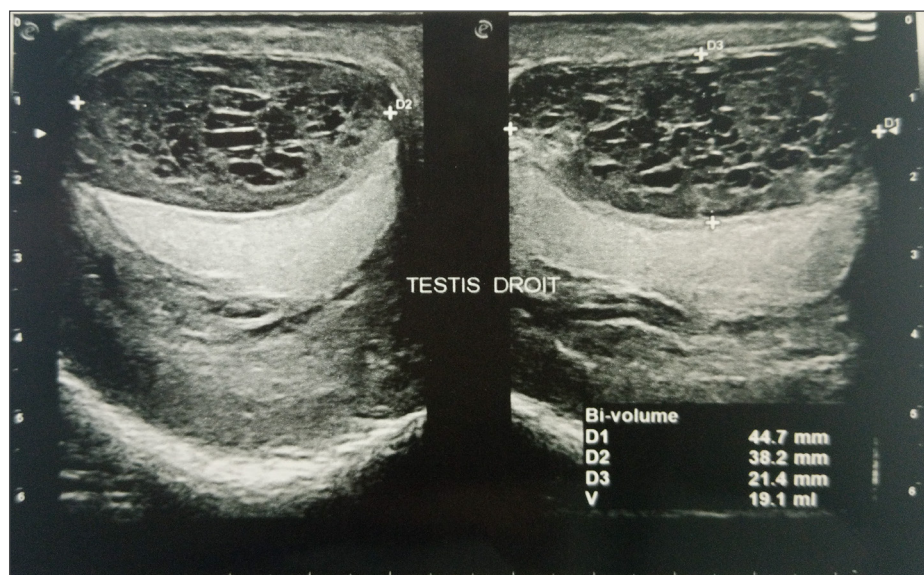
(a, b). Ultrasound depiction of the right testis modified by a heterogeneous structure
